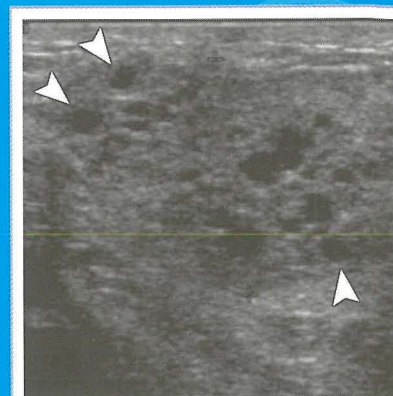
Juvenile papillomatosis appears as a slightly hypoechoic mass that contains multiple, small anechoic cysts (arrowheads) on ultrasound.
